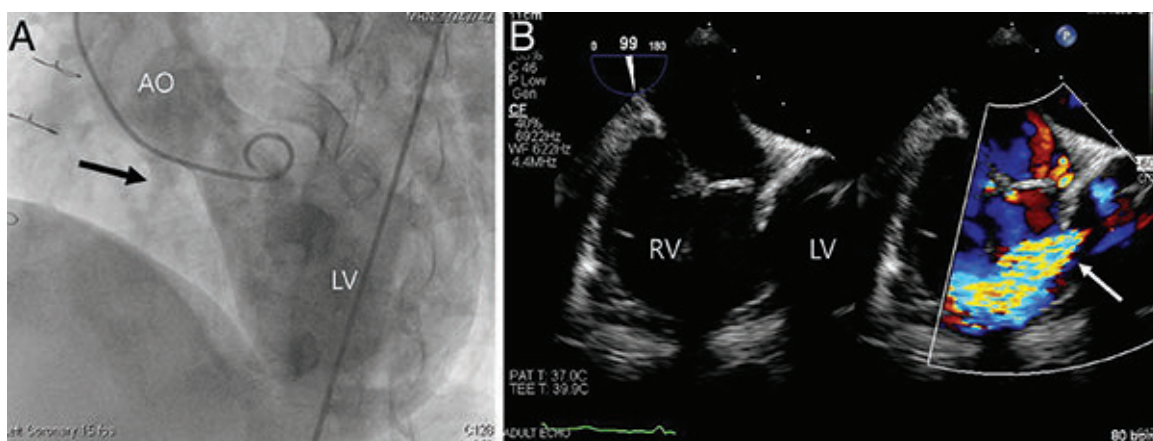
Device closure of residual postoperative VSD with Cocoon VSD occlude device. a LV angiography showed residual VSD (black arrow). b transesophageal echocardiography and color Doppler revealed residual VSD (white arrow) with significant amount.
